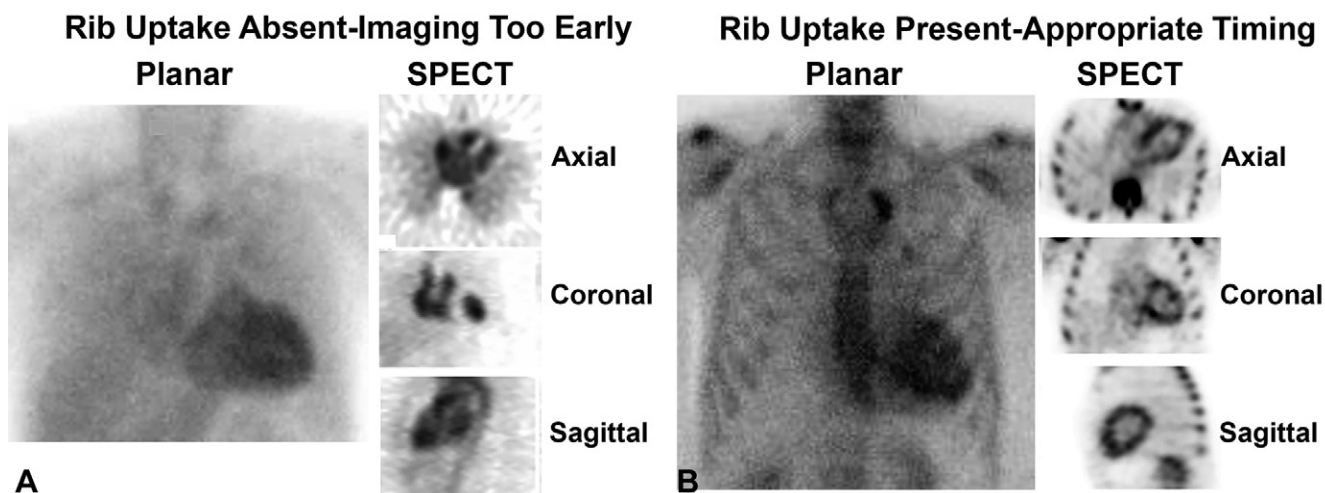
Rib uptake as an indication of appropriate timing of scan acquisition in technetium ^{99m}pyrophosphate cardiac scintigraphy. (A) In the early phase shortly after tracer injection, blood pool activity within the heart is expected, while the ribs and other skeletal structures are not clearly visible. The absence of tracer uptake by the ribs is a good indicator that it is too early to interpret the scan, as the tracer is still circulating in the blood pool and has not entered the myocardium or bound to the bones. (B) In contrast, late images acquired 3 hours after radiotracer injection clearly show tracer uptake in the ribs. Any tracer uptake in the heart on 3-hour images should raise suspicion for myocardial uptake.
